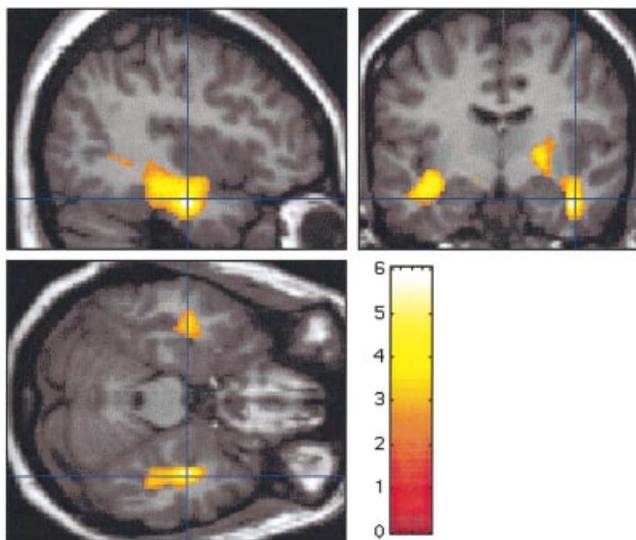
Example of a patient (Patient 5) with increased FMZ- V_d in the TLWM bilaterally. Colour scale: Z score (maximum $Z = 4.45$). Statistical results are overlaid onto the patient's co-registered MRI. Only the ipsilateral TLWM increase (highlighted with a cross-hair) and the contralateral TLWM increase are significant. The left side of the coronal image and the upper part of the transverse image correspond to the left side of the brain.
